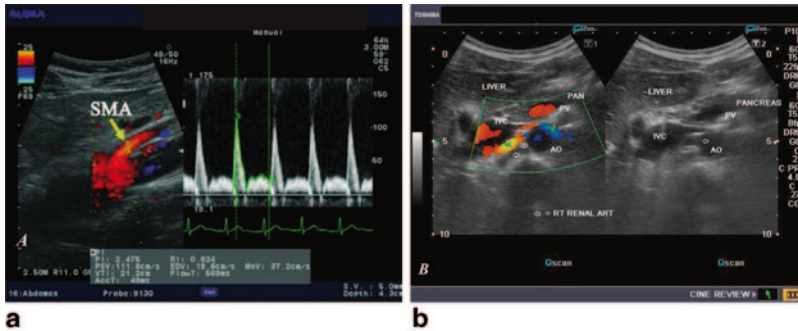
a Color Doppler image of the aorta and the *SMA*. b Grayscale and color Doppler images show the origin of the normal right renal artery from the abdominal aorta (*Ao*), just below the origin of the superior mesenteric artery. It takes careful adjustment of the wall filter settings to remove the motion artifacts from the aortic pulsations, with appropriate pulse repetition frequency (*PRF*) settings to get a good color flow image of the right renal
